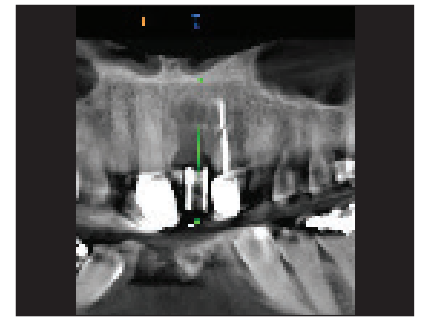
CBCT scan demonstrating implant trajectory in the tangential view in relation to the available bone at the planned site.
